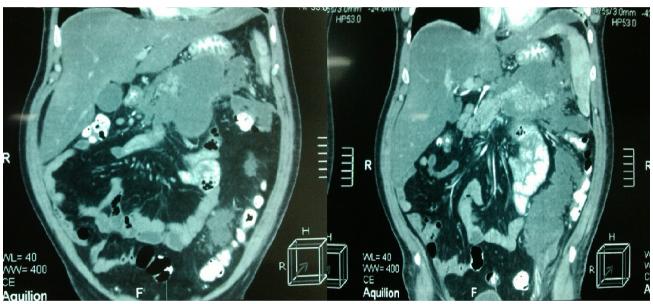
Computed tomography scans showing acute pancreatitis with multiple large acute peripancreatic fluid collections in the lesser sac and one extending to the pelvis.
